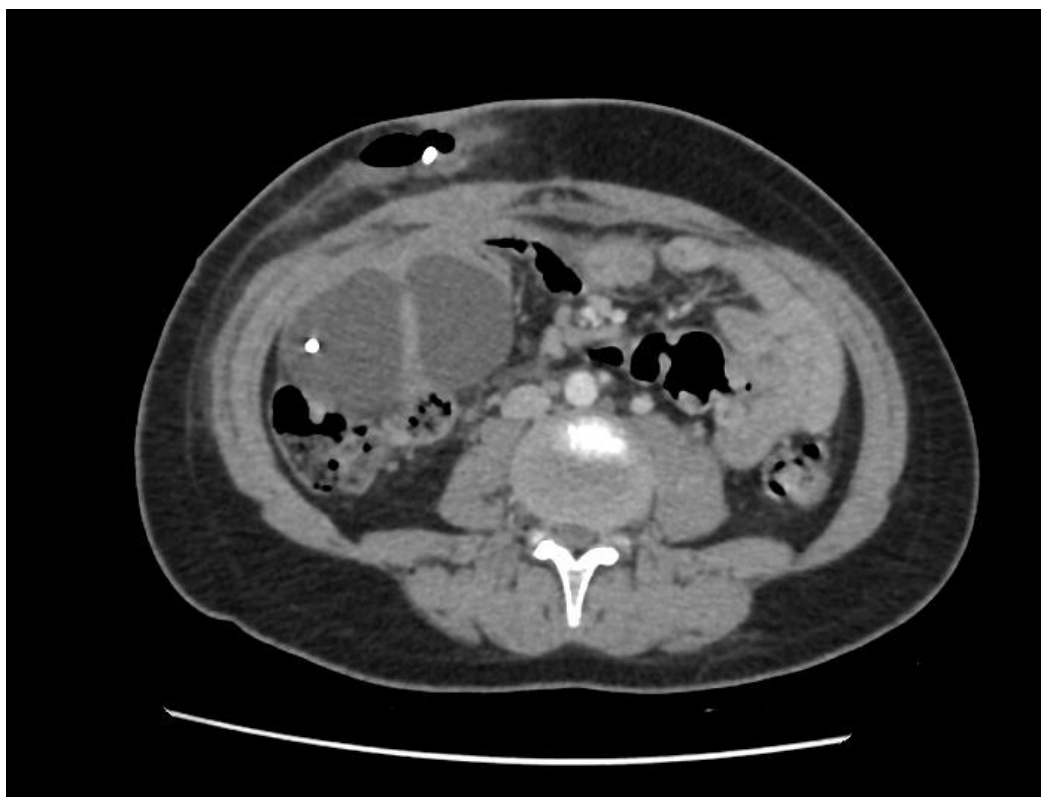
Abdominal CT scan showed pseudocyst abdominal within the tip of abdominal catheter
